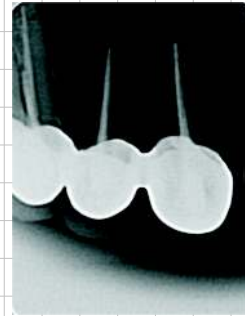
Radiograph during surgery
